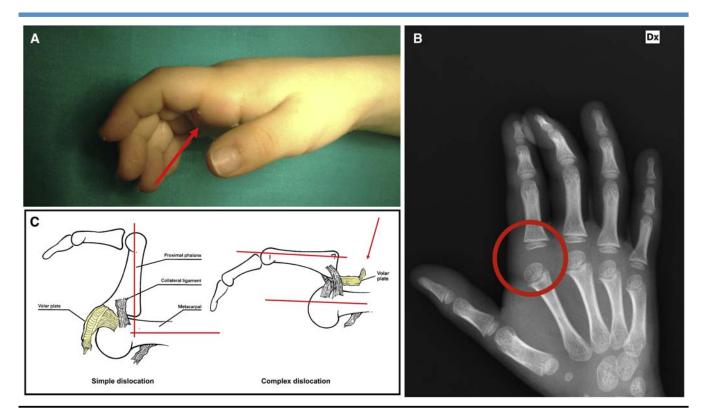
A, Complex dislocation, characterized by the bayonet position of the second finger. B, Anteroposterior radiograph of the right hand injured. C, Note the angle between the proximal phalanx and the metacarpal bone: perpendicular in the simple form, parallel in the complex form. In the latter, the *arrow* points to the palmar plate, which is erroneously displaced between the 2 bone segments. Adapted from Gerrand CH, Jarrett P. A dislocated finger. Postgrad Med J 1998;74:249-51, with editor permission for publication.
